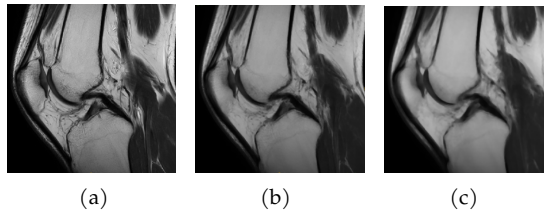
Application of median filter to RM_31 MRI (a) of radius 1 (b) and 2 (c)
